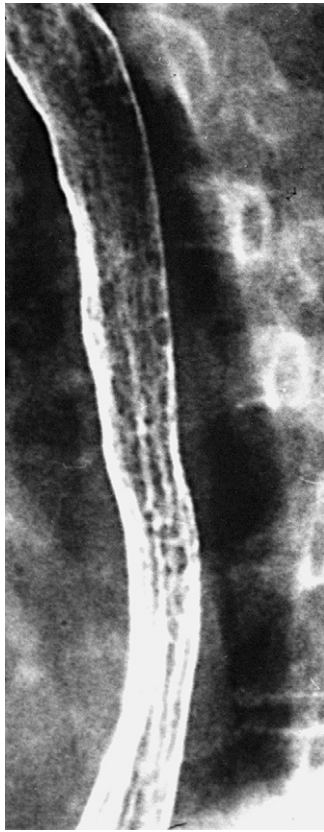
Radiographic contrast study showing mucosal irregularities seen with *Candida* esophagitis.
